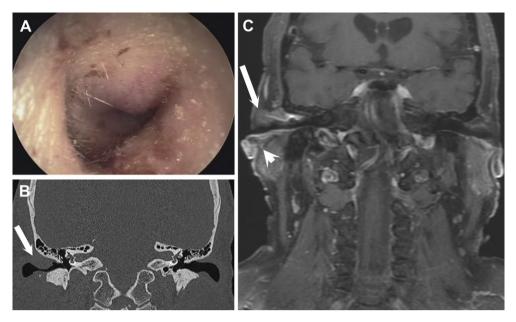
(A) Subcutaneous mass bulging from the superior and posterior aspects of the external auditory canal (EAC). (B) Coronal computed tomography scan of the temporal bone demonstrating a soft tissue mass (arrow) protruding from the superior wall of the EAC. (C) Magnetic resonance imaging shows that the superficial lobe of the parotid gland (arrowhead) and the anterior portion of the temporal bone (arrow) may have been invaded by the mass lesion.
